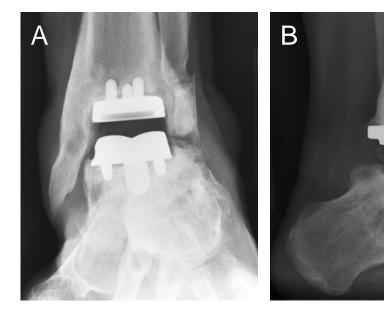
Final weight-bearing x-rays (A, B), at 3 years after TAR.
